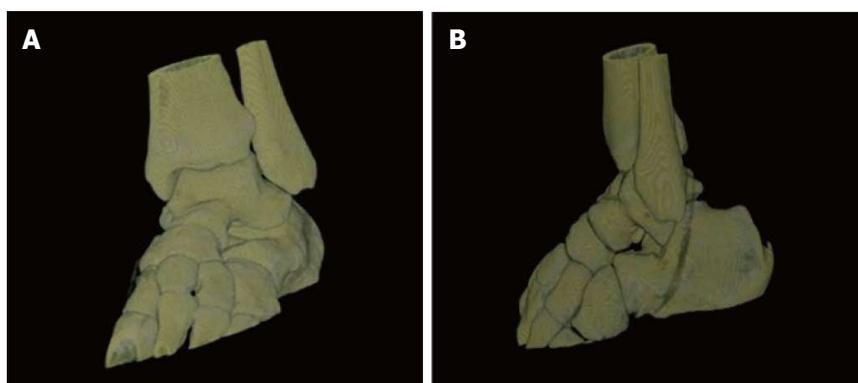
Computed tomography scan with 3D reconstruction images after reduction. There are no intraarticular free bodies. A: Coronal plane; B: Sagittal plane.
